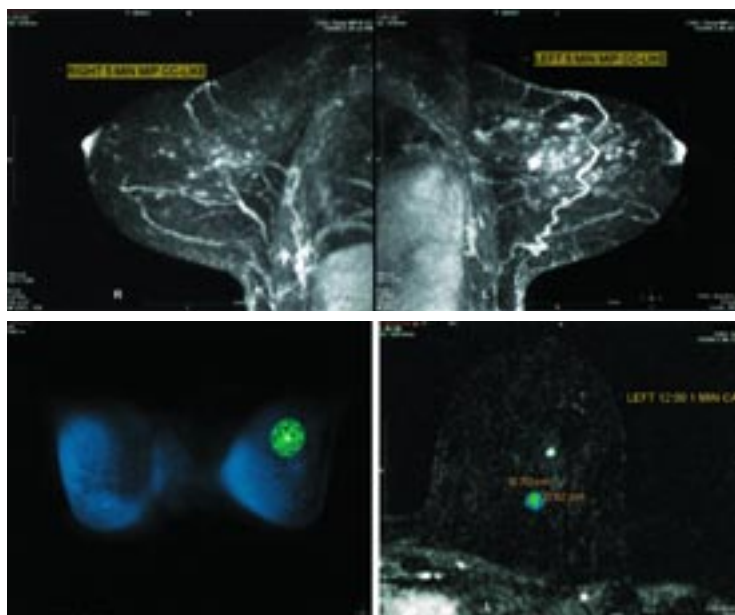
Breast MRI shows abnormal enhancement of a single lesion corresponding in size and location to the left mammographic asymmetry.
